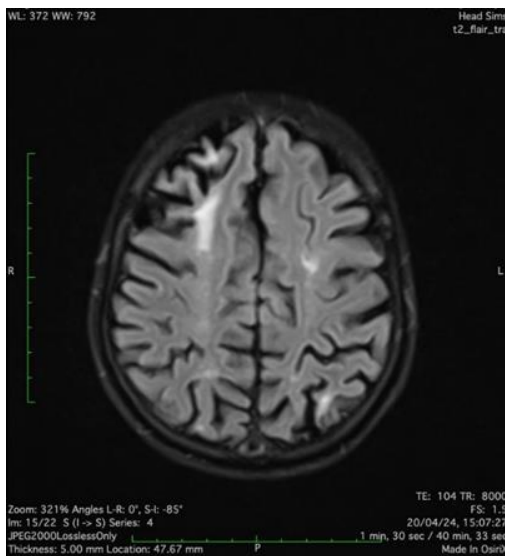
MRI FLAIR axial image shows multi focal hyperintensities .
